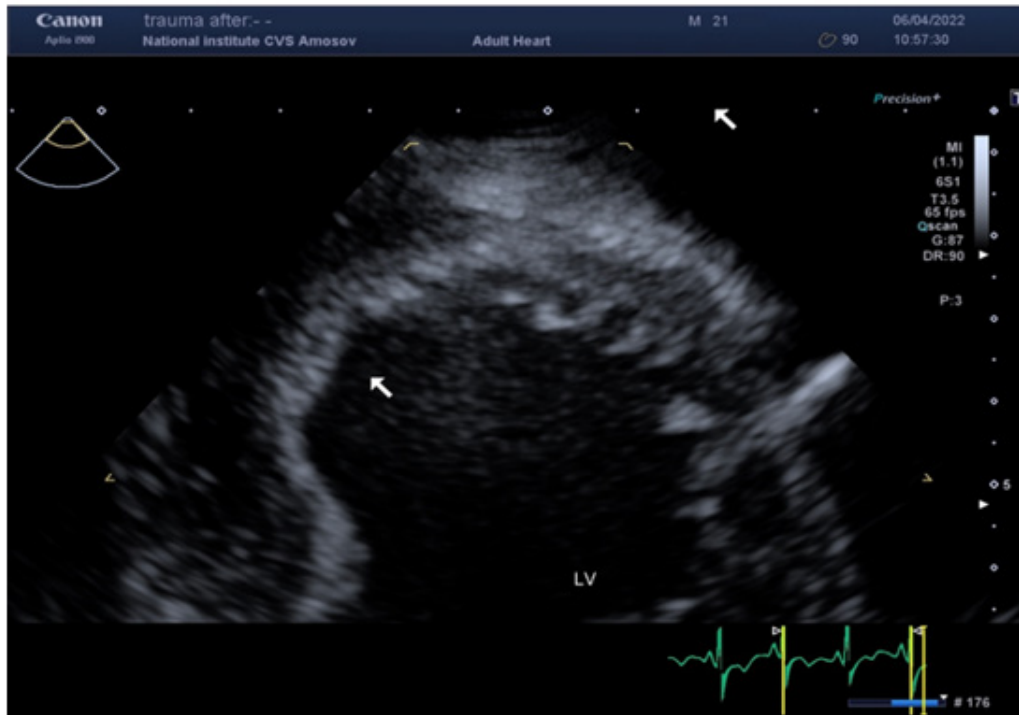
Transthoracic echocardiography, apical 2-chamber view (zoom), showing the affected area (white arrow) - anterior septal LV, LV, left ventricle.
